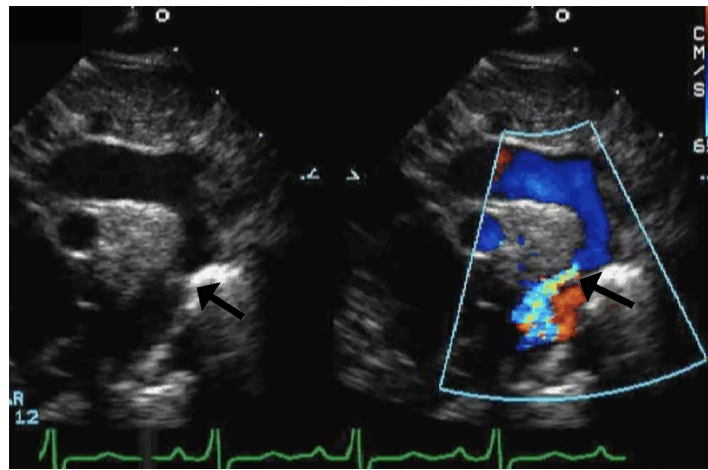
Suprasternal notch view showing a CoA. The CoA (marked with an arrow) is seen as a narrowing in 2D imaging (left panel), where there is color Doppler flow aliasing (right panel).
